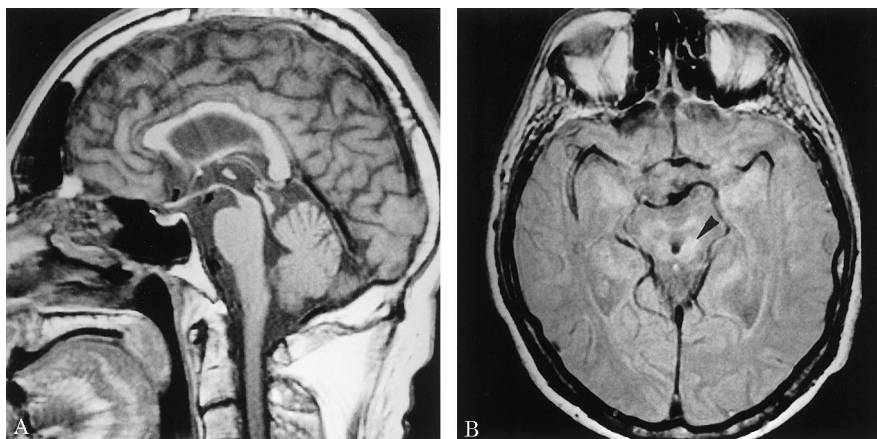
MRI of 59-year-old patient with progressive supranuclear palsy. T1-weighted midline sagittal section (A) shows midbrain atrophy. Axial proton-density image (B) shows slight hyperintensity in dorsal midbrain (arrowhead).
